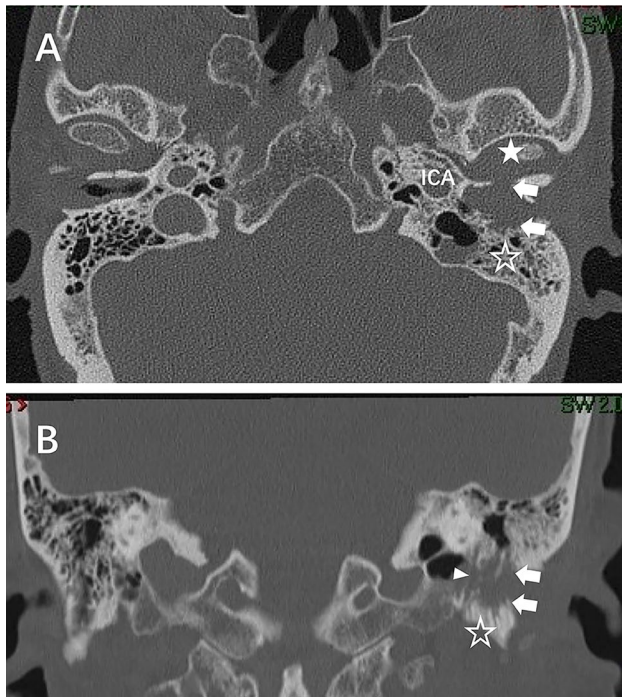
A A patient with T4N0M0 SCC of the EAC. Temporal bone axial HRCT reveals bony erosion of both anterior and posterior walls (arrow) of the EAC. The tumor has invaded the temporomandibular joint (transparent star), mastoid (star) and facial nerve. B Temporal bone coronal HRCT demonstrates bony erosion of both the superior and inferior walls (arrow) of the EAC. There is invasion into the fallopian canal (triangle) and tympanic bone (transparent star). *ICA*: internal carotid artery
